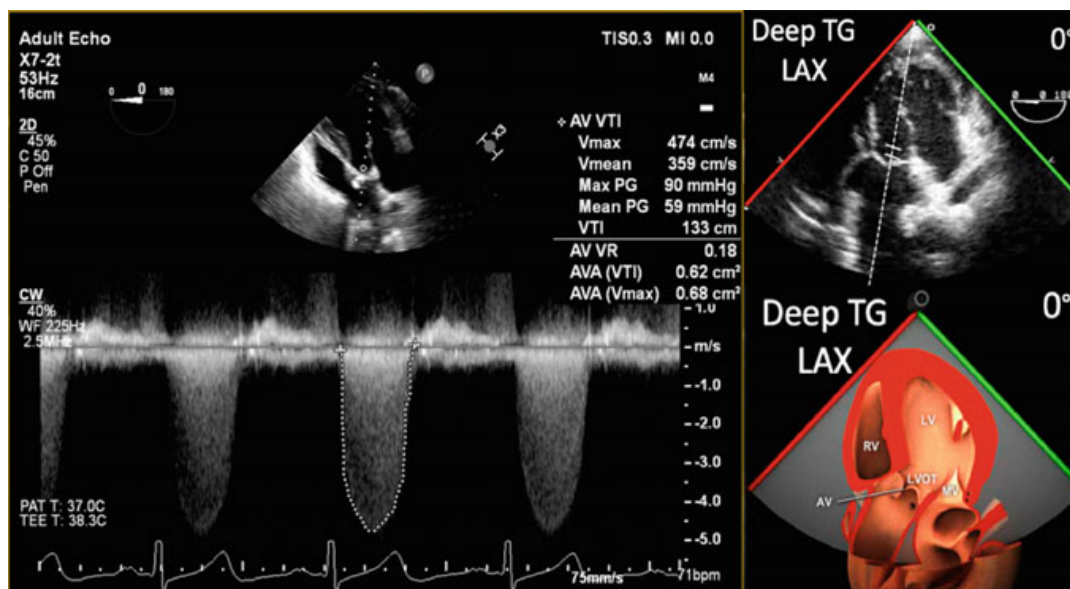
Severe aortic stenosis with mean transvalvular pressure gradient (Mean PG) determined by Bernoulli equation derived from the aortic valve peak velocity (V_{max}) and aortic valve area (AVA) by continuity equation (VTI). Parameters obtained from a long axis (LAX) aortic valve deep transgastric (TG) transesophageal echocardiography (TEE) view. Modified from pie.med.utoronto.ca
